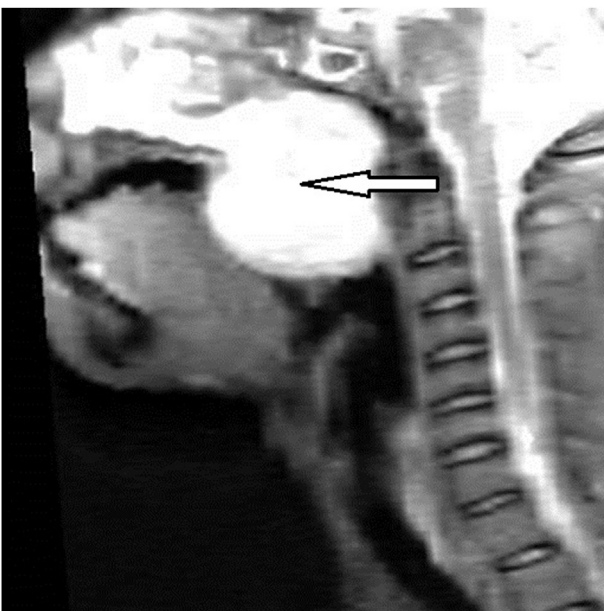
MRI reconstruction - Arrow shows a nasopharyngeal mass extending from posterior aspect of nasopharynx to the hypopharynx, significantly narrowing the oropharyngeal airway at the tongue base.
